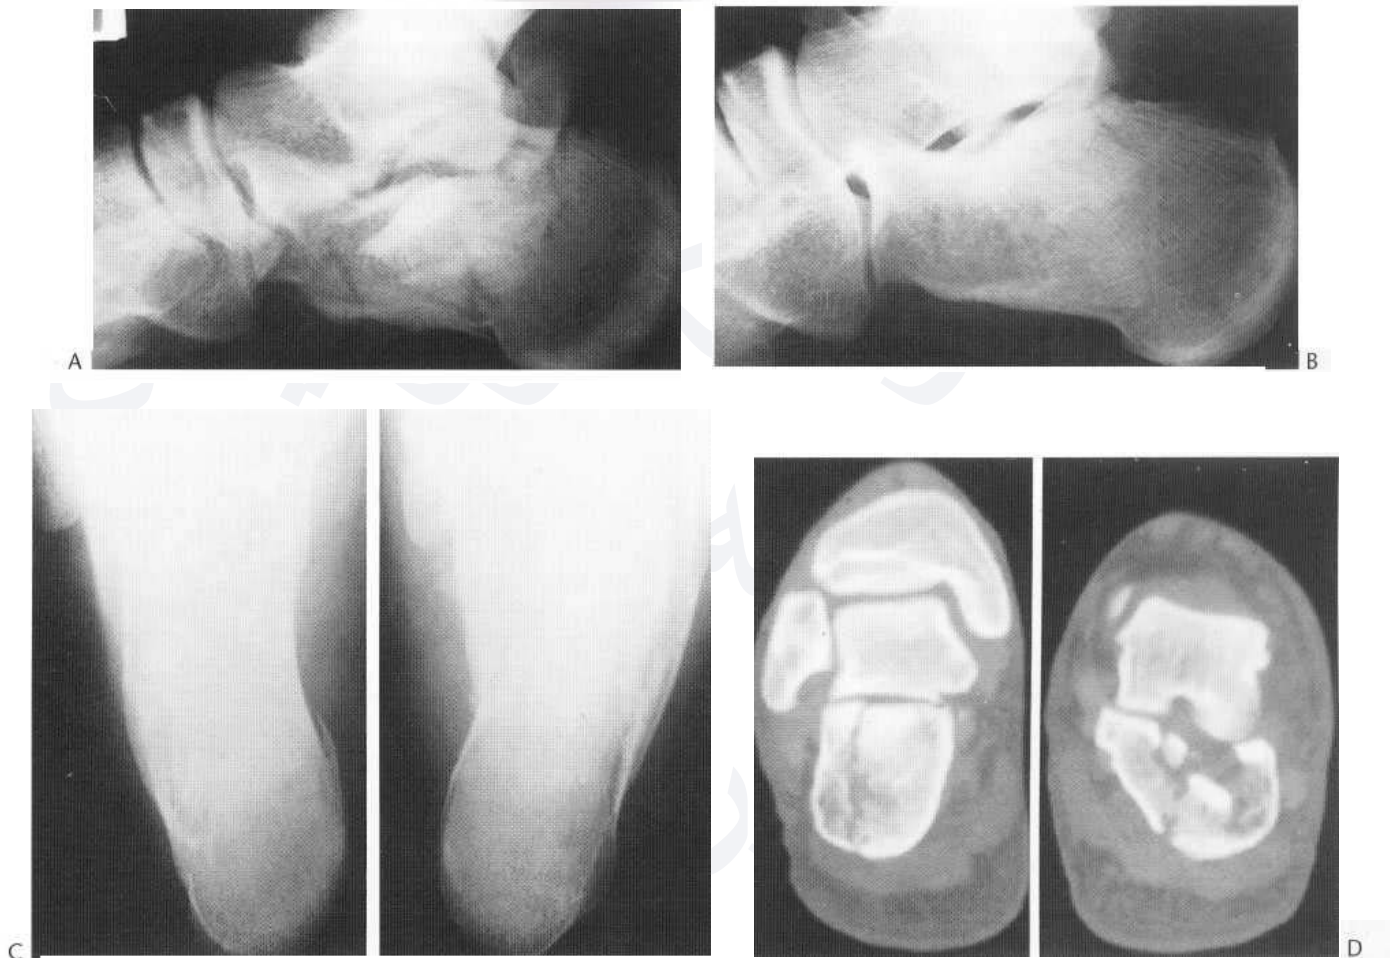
Comminuted fractures of both calcanei. The extent of the injury, and in particular of the articular involvement, is poorly displayed by the plain radiographs (A-C) particularly on the right. (D) CT images, however, demonstrate that there is an obvious disorganisation of fragments at the articular surface on the left, and a mildly depressed segment on the right.
